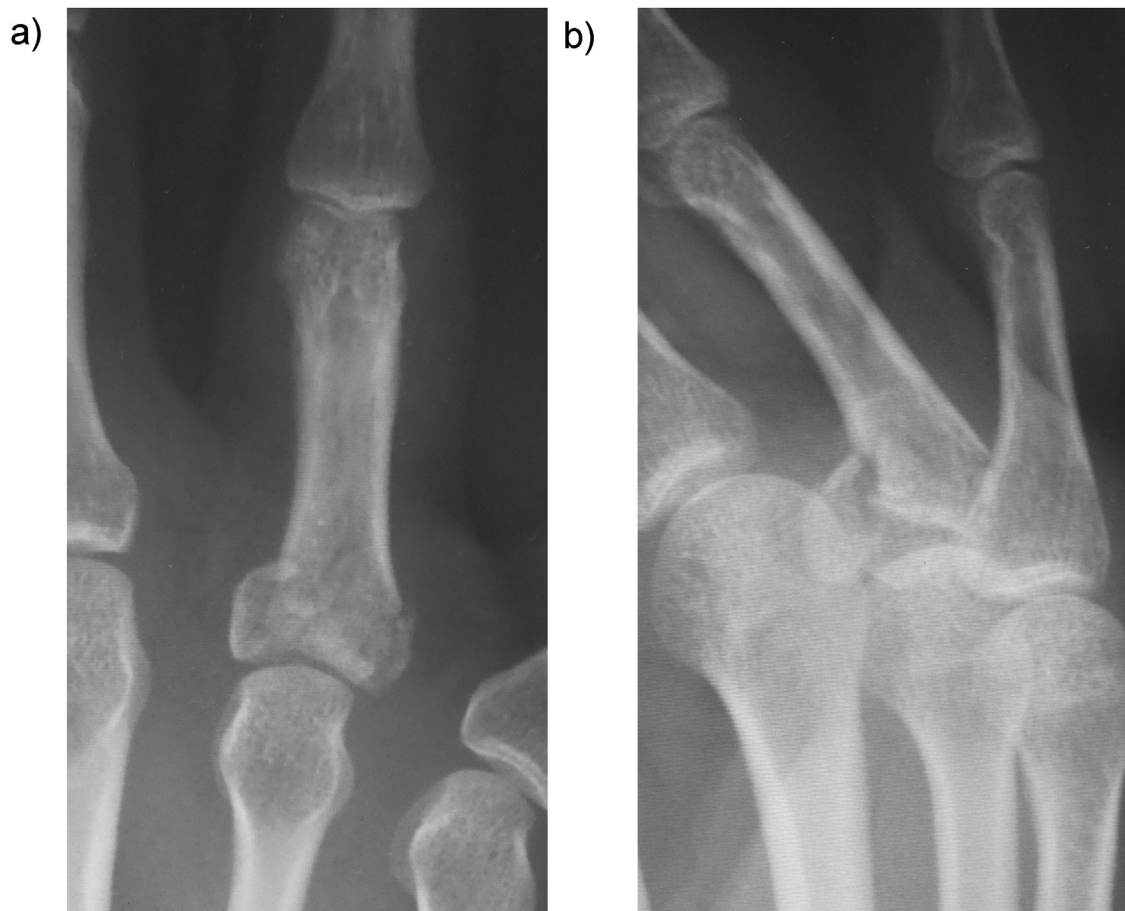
Preoperative X-ray showing a comminuted intraarticular fracture of the base of the proximal phalanx of the ring finger.
